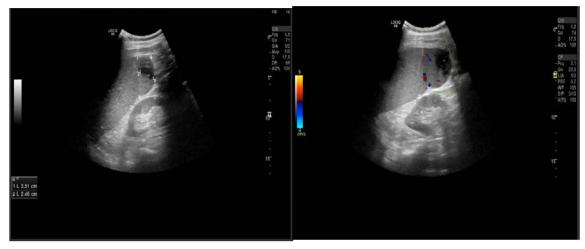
Ultrasound of upper abdomen showing enlarged spleen with an ill-defined hypoechoic areas seen in the spleen with no vascularity seen on color doppler
